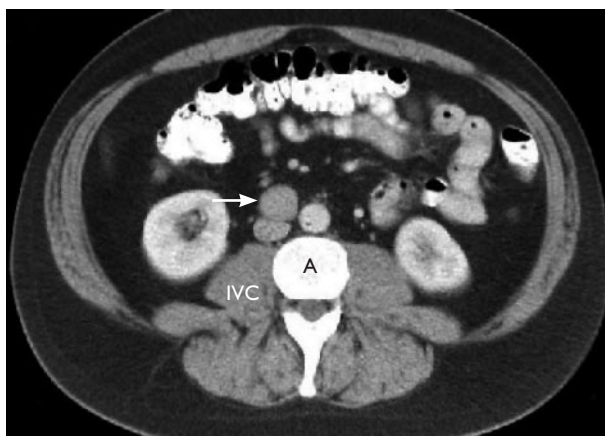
Abdominal computed tomography scan showing an enlarged retroperitoneal lymph node (arrow) compressing the inferior vena cava (IVC) anterolateral to the abdominal aorta (A).
